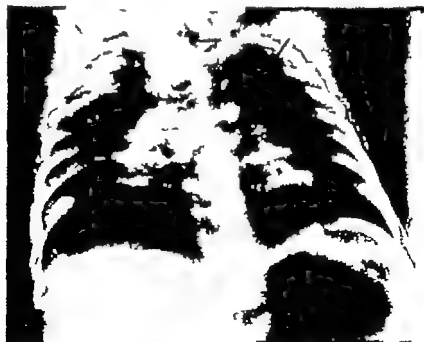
Chest X-ray, anterior view. Marked cardiac dilation, anomalies of the spine and ribs, as noted, consistent with Kippel-Feil syndrome (see arrows).
